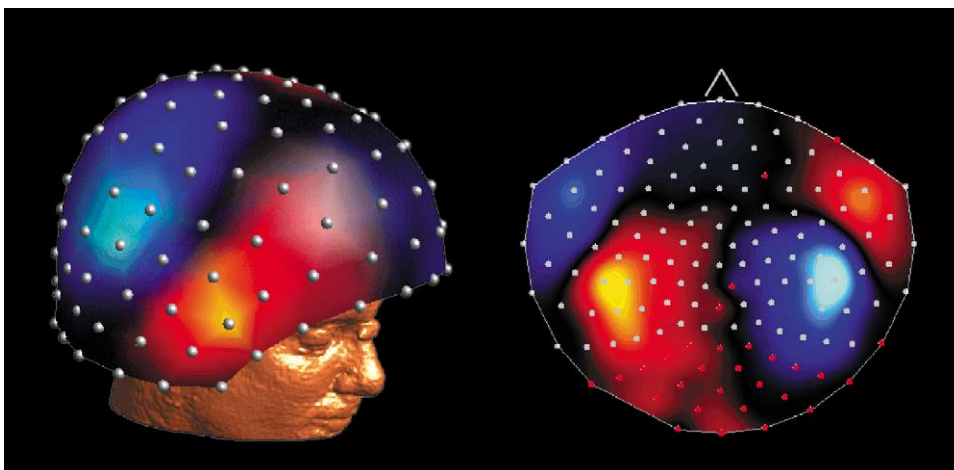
(Left) Example of averaged magnetic activity from an N1m response interpolated with a spline of 3rd order and placed over a reconstructed MRI image. White dots represent the positions of the sensors relative to 3 fiducial points (nasion, and left and right preauricular points). Light-blue/blue coloring indicates field lines entering the head; in yellow/red regions field lines exit. (Right) Two-dimensional polar projection of the same pattern of activity. The nose points to the top of the figure. Bilateral dipolar fields imply activity within both auditory cortices. Sensors colored red were not included in the analyses due to a high noise level.
